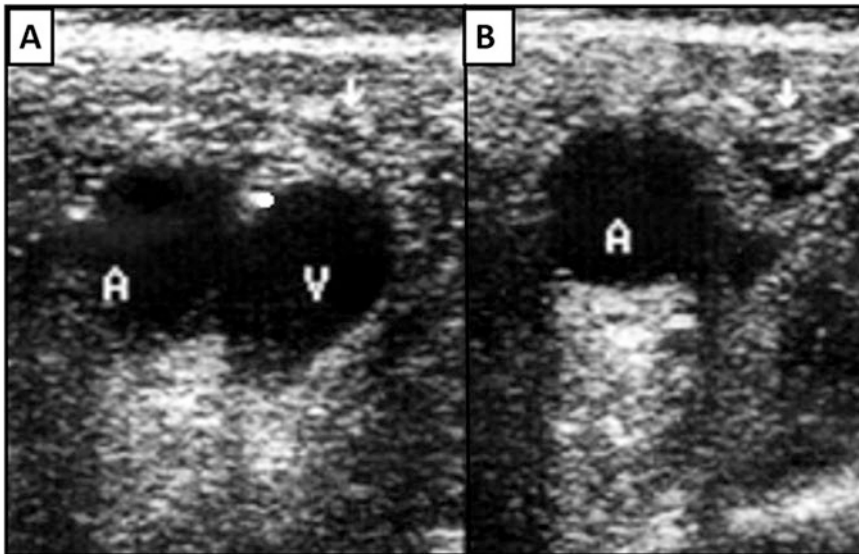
Ultrasound images of compression testing of a normal vein. Vein seen before compression. (a) Under compression (image on the *right side*), the vein is not seen
